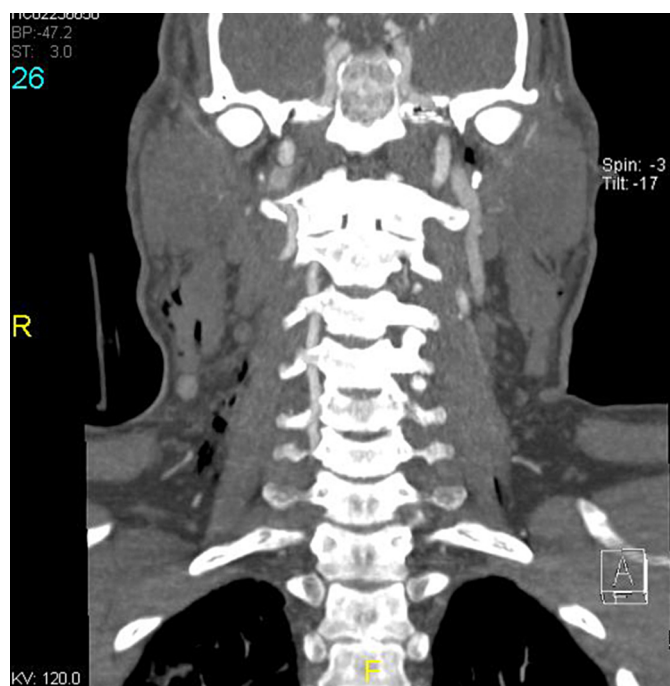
CT angio: Left vertebral artery occlusion.
